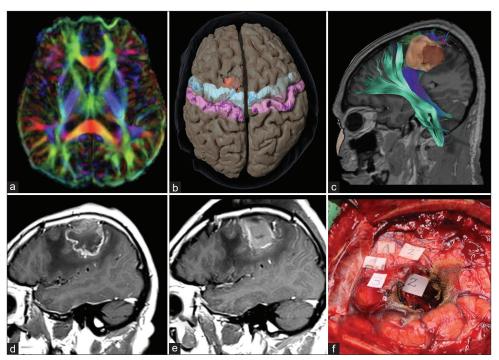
Regions of interest used for fiber tracking. (a) Diffusion tensor imaging demonstrating selection of region of interests (ROIs) in the posterior limb of the internal capsule bilaterally. (b) The selection of ROIs in the precentral and postcentral gyri bilaterally is demonstrated. (c) Tractography reconstruction of descending motor pathway and the corticospinal tract in relationship with a left frontal tumor is shown. Preoperative (d) and postoperative (e) T1 postcontrast sagittal magnetic resonance imaging demonstrate a gross total resection of the tumor. (f) The intraoperative visualization of cortical and subcortical mapping with direct stimulation demonstrates the corresponding areas of the left shoulder (3), arm (2), and hand (1).
